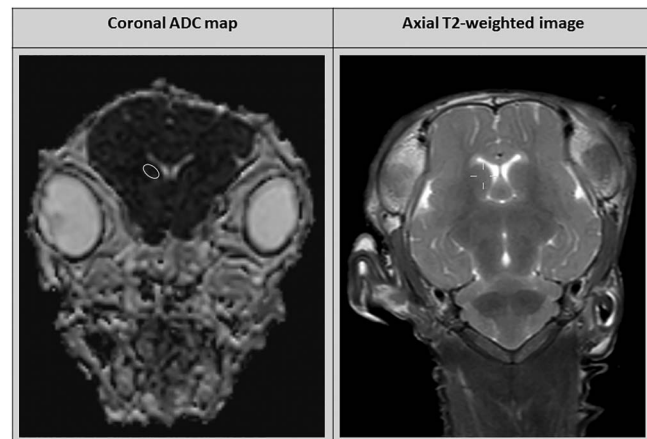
Example of ROI placement in a coronal ADC map ($b = 1000$) in the right basal ganglia (left) and axial T2-weighted image for cross-referencing (right). ADC, apparent diffusion coefficient; ROI, regions of interest.
